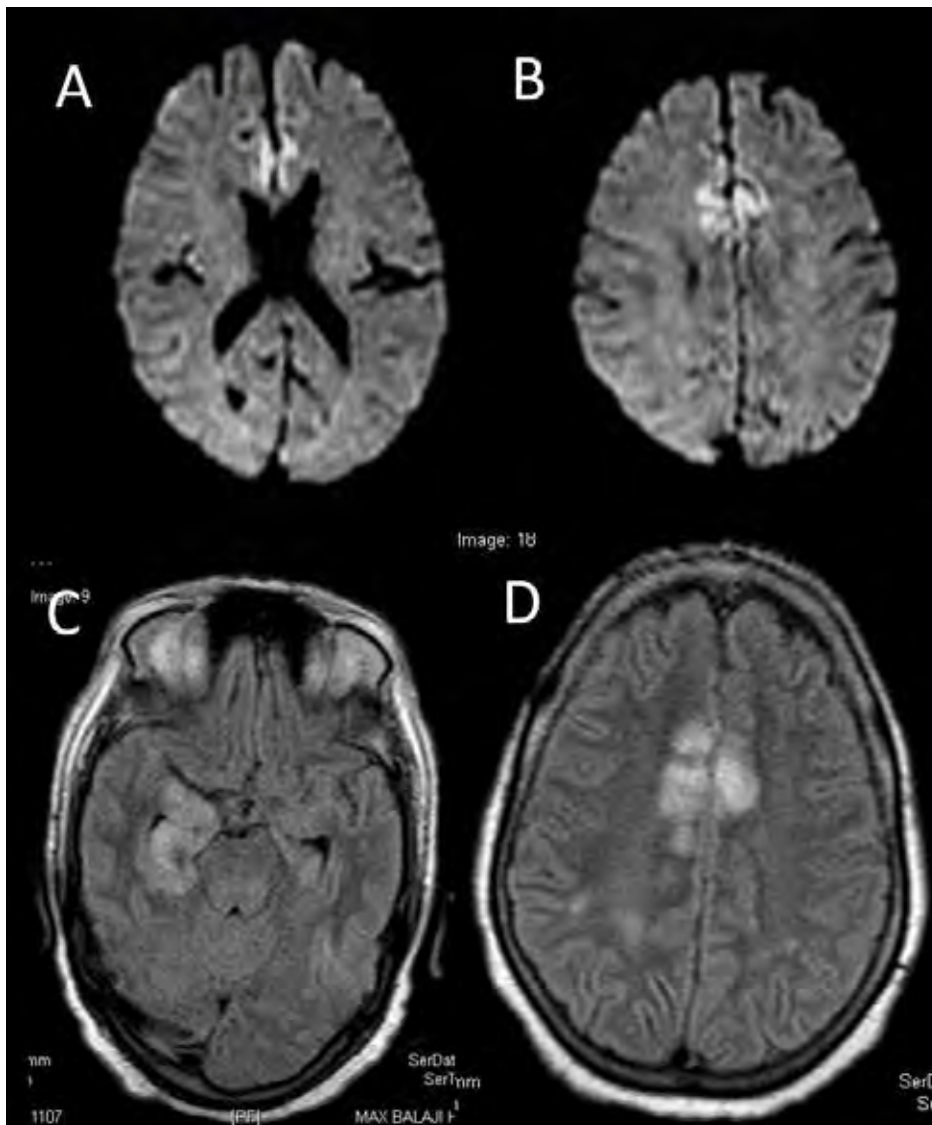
Demonstrates hyperintensity on DWI sequence (A and B) in bilateral parafalcine area. FLAIR hyperintensity is also seen in bilateral temporal and parafalcine areas (C and D).
